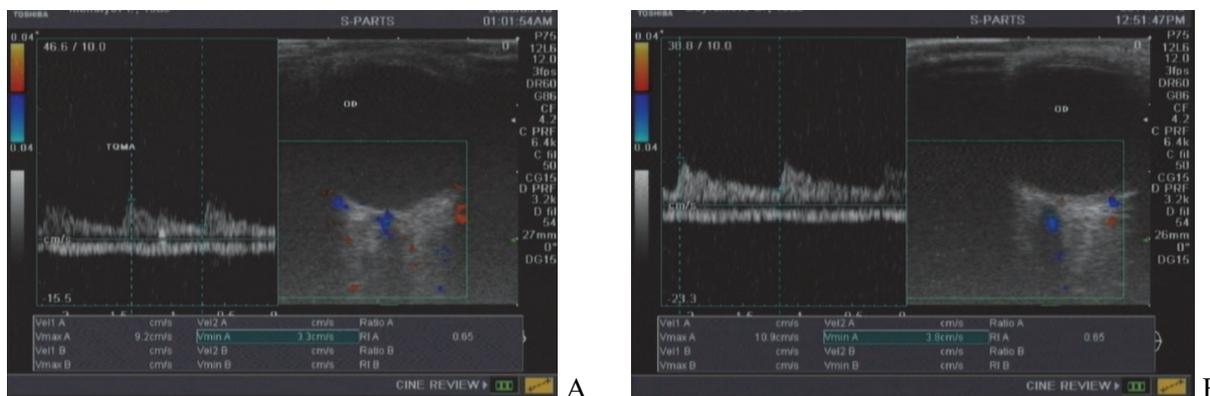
Doppler ultrasonography of CRA. A – before treatment. B – after treatment.
